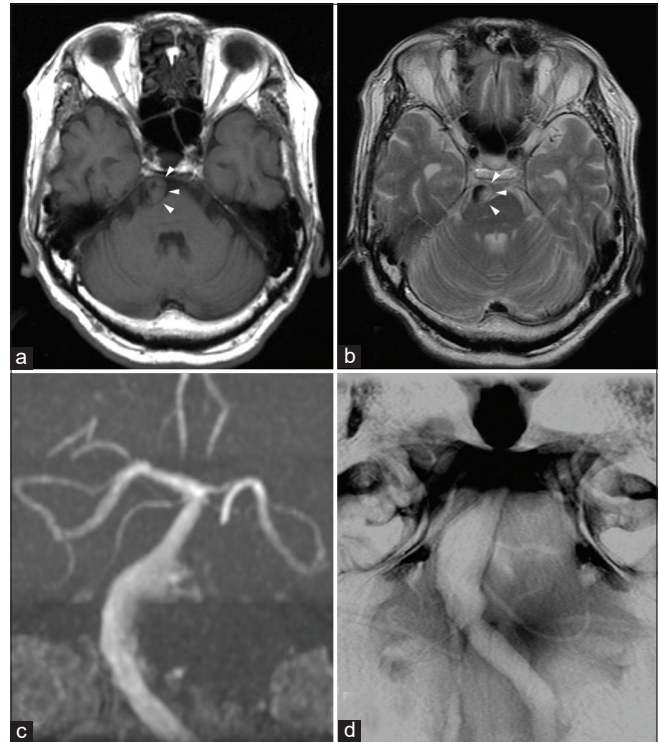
Magnetic resonance imaging (MRI) findings obtained on admission. Axial T1-weighted (a) and T2-weighted (b) MRI showing a narrowed eccentric flow void surrounded with intramural hematoma (arrowhead) that expands the basilar artery diameter. MR angiography (c) and basi-parallel anatomical scanning (d) showing focal dilatation of the basilar artery.
